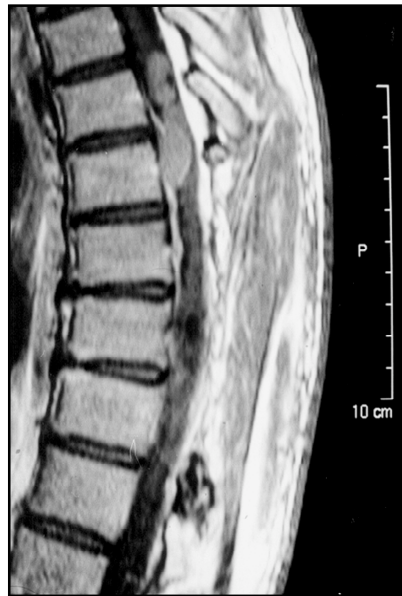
MRI shows two tumors at the T6-T7 level.
